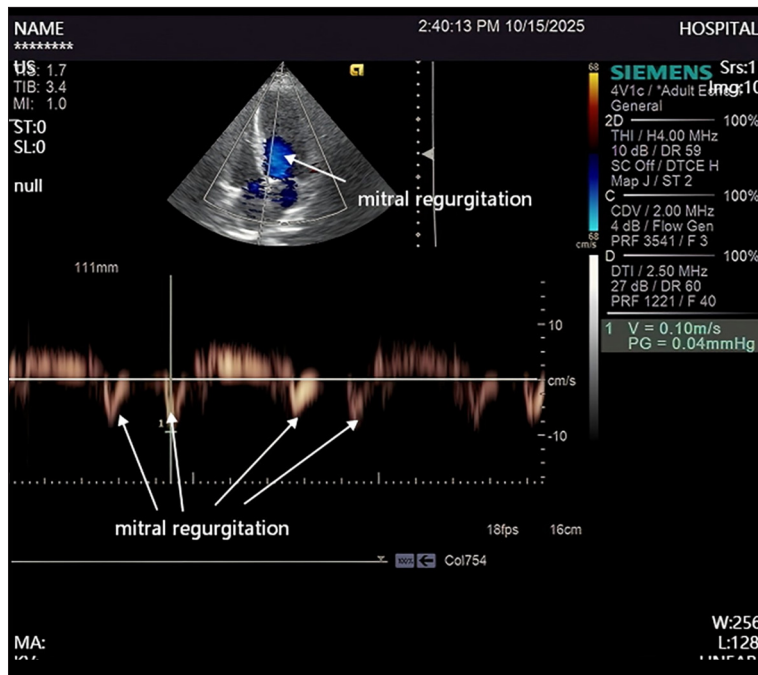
Echocardiographic images demonstrating mild mitral and tricuspid regurgitation, preserved left ventricular systolic function (left ventricular ejection fraction = 65%), and no regional wall motion abnormalities.
